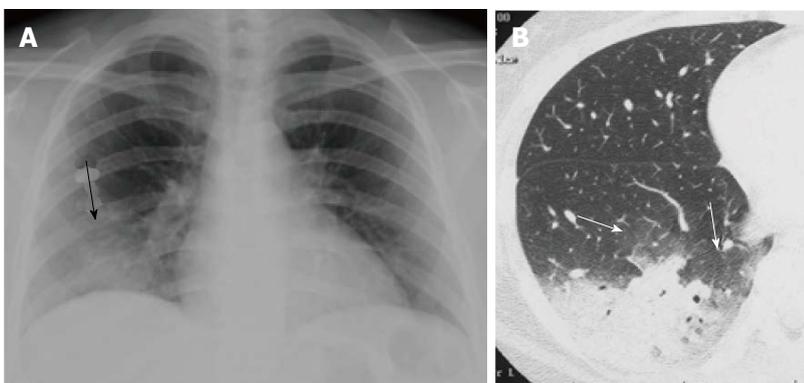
Mycoplasma pneumoniae* pneumonia showing alveolar pneumonia in a woman in her 30s. A: Chest radiograph demonstrates ill-defined consolidation in the right lower lung field (arrow); B: Thin-section CT reveals a non-segmental consolidation with air bronchograms at the dorsal aspect of the right lower lobe. Areas of ground-glass opacity are also noted around the consolidation (arrows). CT: Computed tomography.
